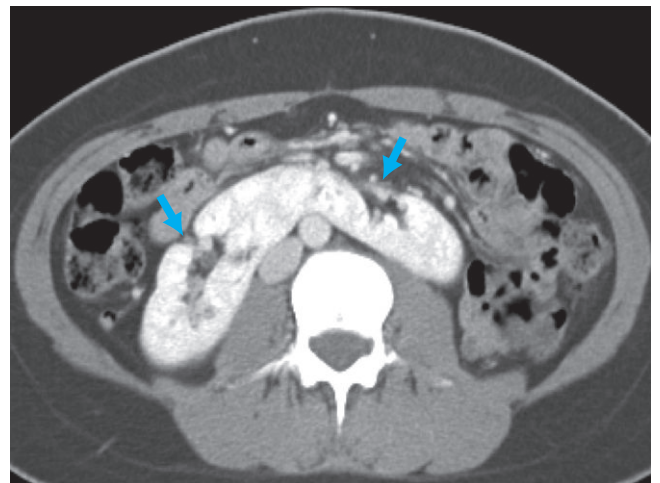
Contrast-enhanced CT image demonstrating a horseshoe kidney. Note the aberrant orientation of the collecting systems pointing anteromedially (arrows).
